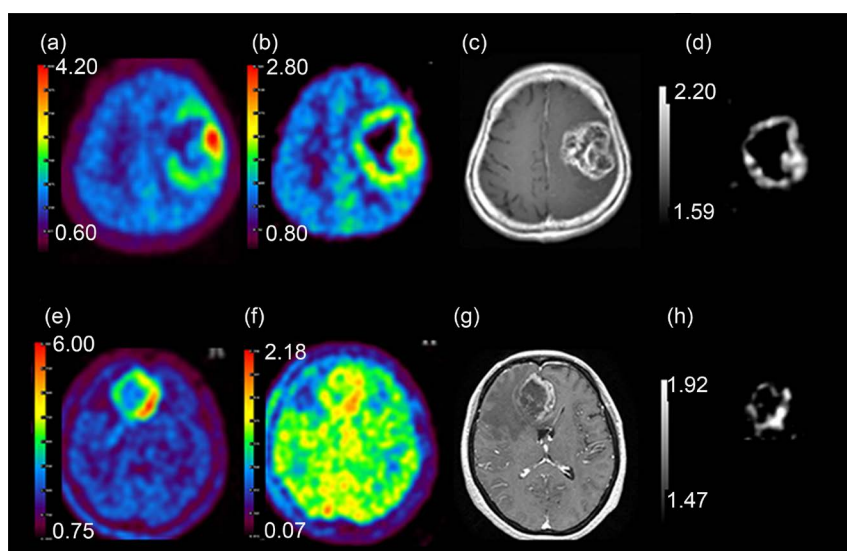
Representative images for Case 3 (a) (d), and Case 4 (e)-(h) in Table 1. (a) (e) MET PET; (b) (f) FRP170 PET; (c) (g) gadolinium-enhanced T1-weighted magnetic resonance imaging; (d) (h) extracted pixels between SUVmin and SUVmax in tumor.
